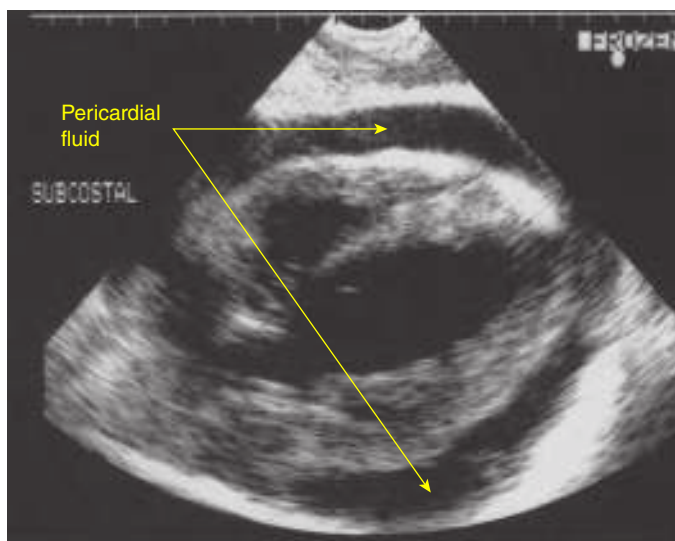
Free pericardial fluid is visualized as an anechoic stripe surrounding the heart. (Modified with permission from Ma OJ, Mateer JM, Blaivas M: *Emergency Ultrasound*, 2nd ed., McGraw-Hill, 2008.)
